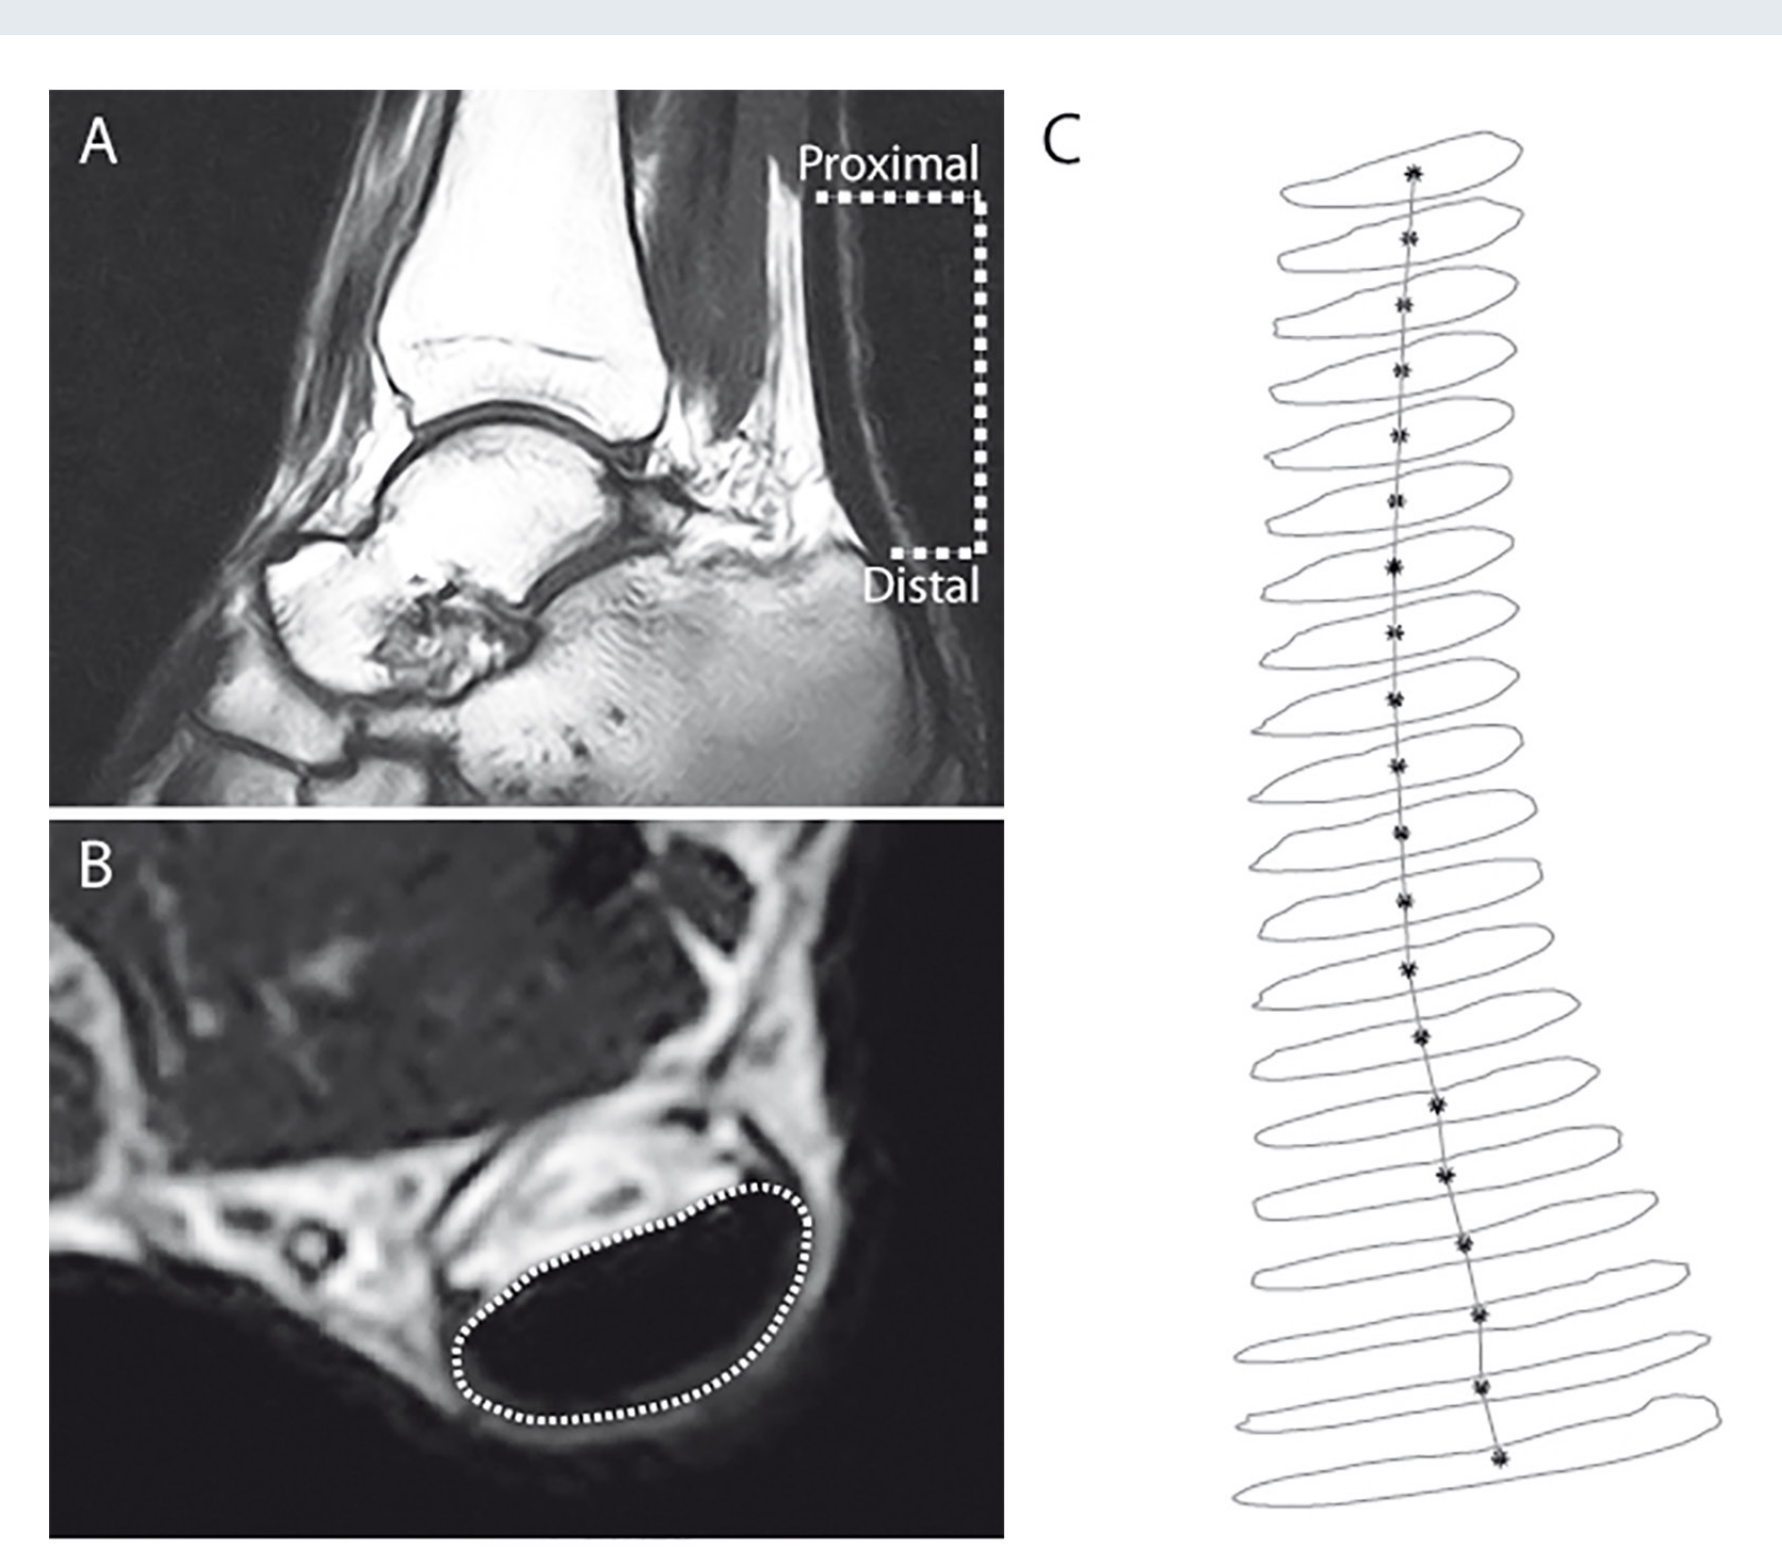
Sagittal (A) and transverse (B) magnetic resonance images were used to investigate morphological free Achilles tendon properties (i.e. length and cross-sectional area; C).
